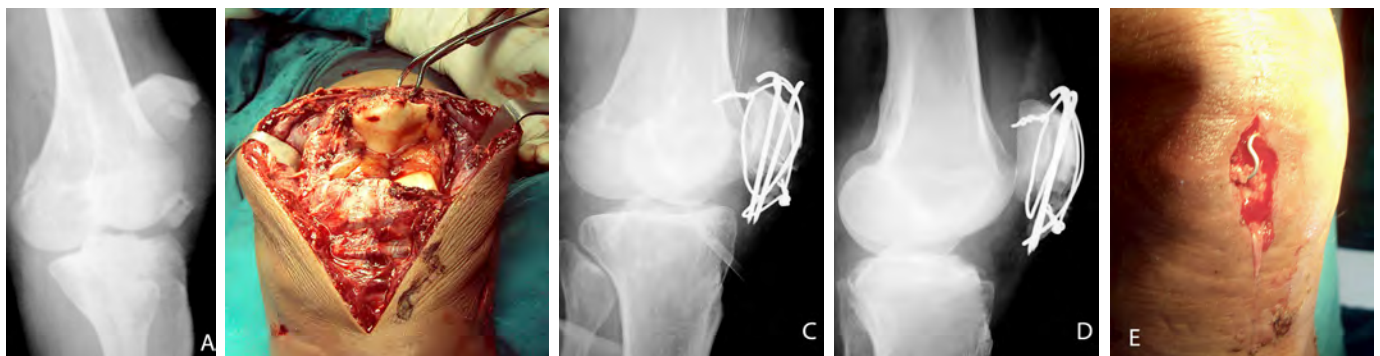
A 45-year-old man fell from height and sustained a displaced patellar inferior pole fracture; (A) Oblique radiograph of the comminuted inferior avulsion fracture without articular extension; (B) Intraoperative photograph shows extra-articular location of the fracture with complete disruption of retinaculum; (C) Postoperative lateral radiograph shows fracture reduction and internal fixation with TBW and circumferential wiring; (D,E) Six months post surgery lateral radiographs shows fracture non union with infection and exposed end of wire.
